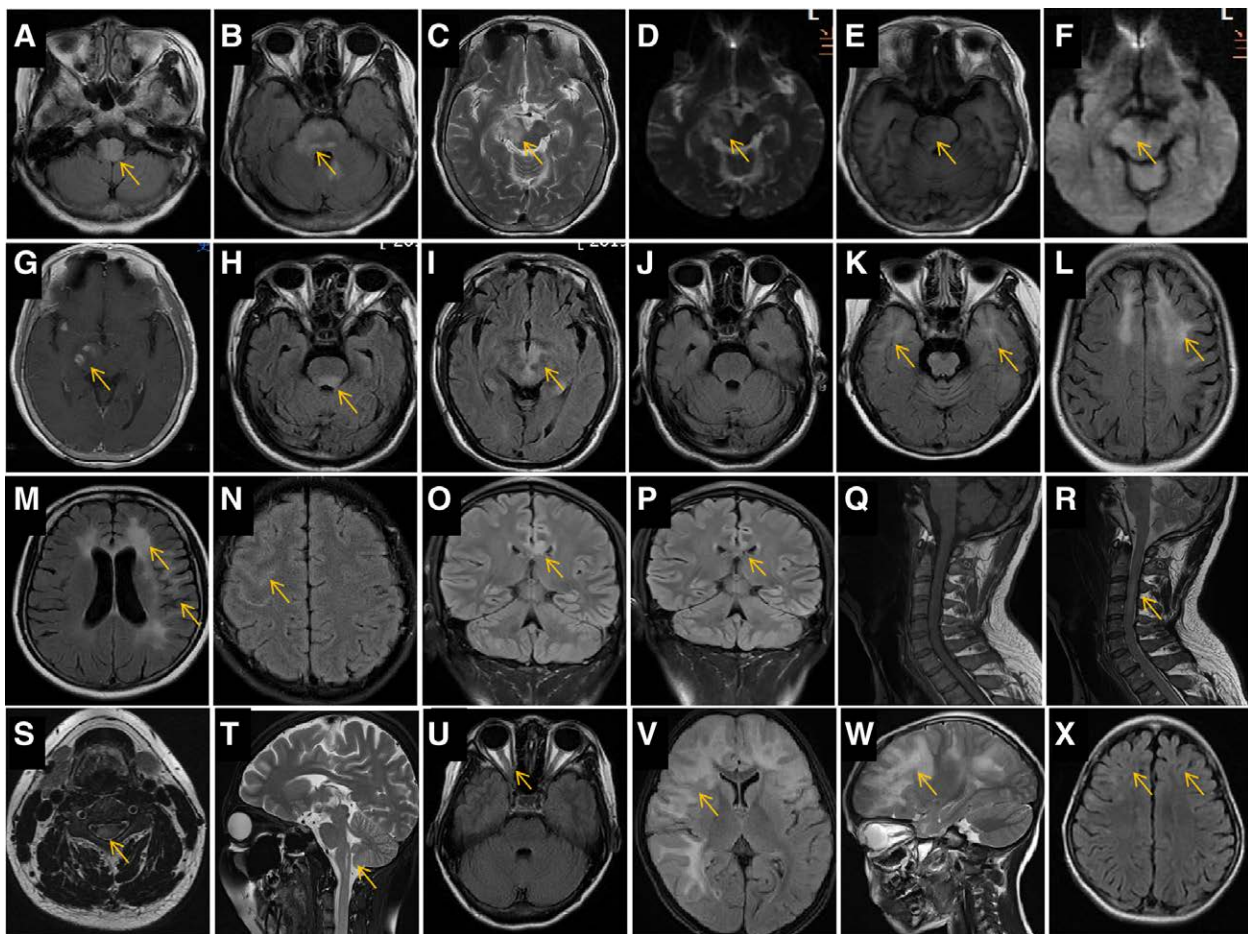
Characteristics and lesion evolution in brain magnetic resonance imaging (MRI) of representative cases. •Patient 1. Initial brain MRI showing hyperintense regions in the bilateral medulla oblongata (A, arrow), pons (B, arrow), right pedunculus cerebri, and right midbrain (C, arrow) on fluid-attenuated inversion recovery (FLAIR, A and B, arrows), T2-weighted imaging (WI, C, arrow), and apparent diffusion coefficient (D, arrow), hypointense on T1WI (E, arrow), and without diffusion restriction on diffusion-weighted imaging (DWI, F). Several spot-like enhanced lesions are noted in the right pedunculus cerebri (G, arrow). •Patient 2. Initial MRI showing hyperintense regions in the right pedunculus cerebri (G, arrow), midbrain, and areas around the third ventricle (I, arrow) on FLAIR. The hyperintense signal in the brainstem FLAIR disappeared 1 mo later (J). •Patient 3. FLAIR MRI showing a hyperintense signal in the bilateral temporal poles (K, arrow), frontal white matter regions (L, arrow), anterior horns of the lateral ventricle (M, arrow), and cortical and subcortical regions in the left temporal lobe (M, arrow). •Patient 4. FLAIR MRI showing a hyperintense signal in the right frontotemporal lobe sulcus (N, arrow). •Patient 5. Initial FLAIR MRI showing a hyperintense signal in the corpus callosum body (O, arrow); the hyperintense signal nearly disappeared on MRI 3 mo later (P, arrow). •Patient 6. Initial sagittal T1WI MRI of the cervical spinal cord showing isointense signal (Q, arrow) and short, segmental hyperintense signal in the sagittal (R, arrow) and axial (S, arrow) T2WI. •Patient 7. MRI 1 mo after onset showing a small syringomyelia (T, arrow). •Patient 8. Brain MRI showing slight thickening of the right optic nerve (U, arrow). •Patient 9. MRI showing a large hyperintense area on T2WI in the bilateral frontotemporal lobes, mimicking a tumor (V and W, arrow); MRI performed 8 mo later showed that the abnormal signals nearly disappeared, with slight brain atrophy (X, arrows).
